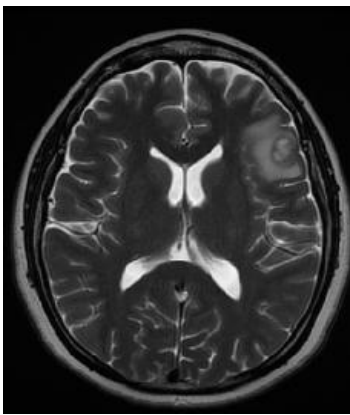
MRI of the brain with contrast enhancement showed an enhancing lesion in the left frontal lobe at the gray-white junction with mild perilesional edema measuring 1.3 x 1.5 x 1.1 cm suggestive of metastatic disease.
